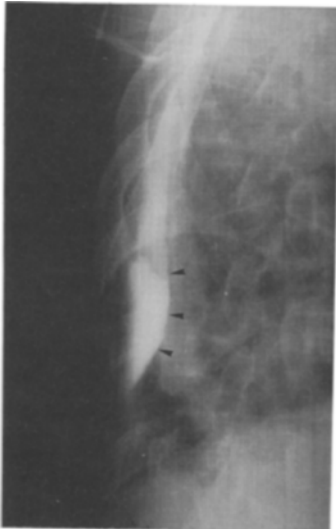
Lateral chest radiograph of the same subject as in figure 2, showing that the contrast medium is in the extrapleural space separating the pleura from its attachments over a few adjacent ribs (arrowheads).
